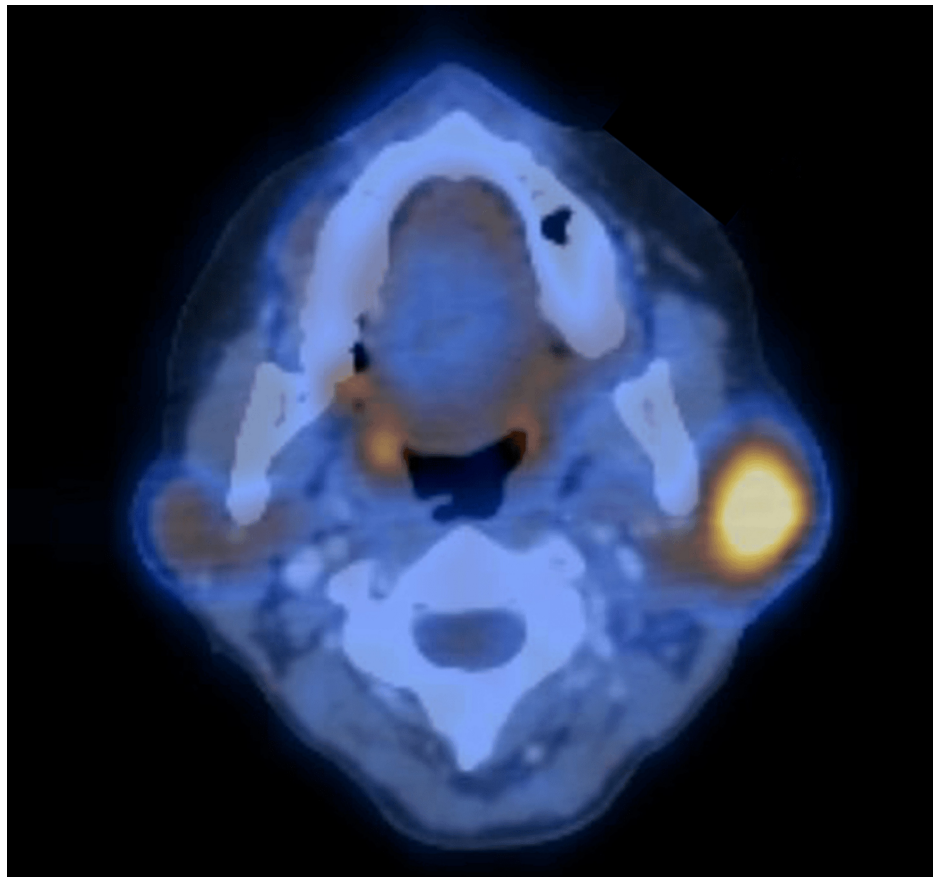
Axial fused FDG PET-CT image at the level of the parotid glands, obtained at diagnosis.
